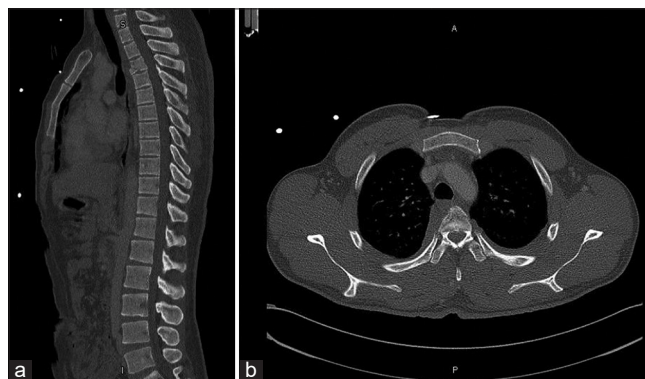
(a and b) Sagittal and axial cut CT scan showing the fracture of the 3rd thoracic vertebra (D3).
